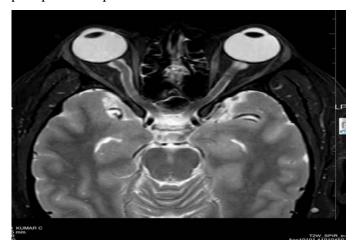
MRI Brain showing vertical tortuosity of right optic nerve
